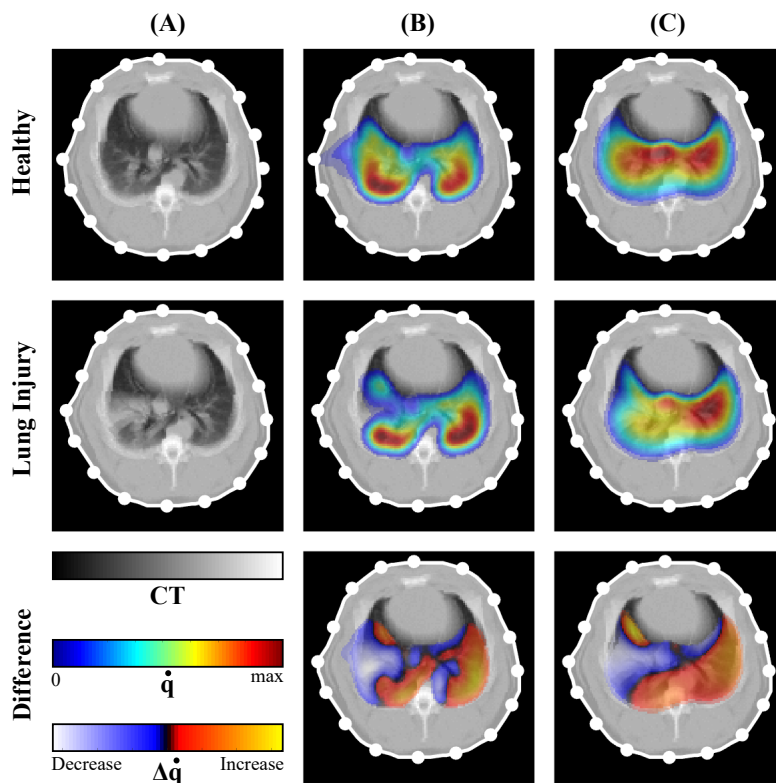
Estimated pulmonary perfusion distributions before and after sublobar lung injury. Static CT images (A) are shown alongside of the computed MDCT blood flow $\dot{q}_{CT,PCB}$ (B), the calculated EIT blood flow \dot{q}_{EIT} (C) for the healthy (upper row), and the injured lung (middle row). The spatial perfusion increase or decrease ($\Delta\dot{q}_{CT,PCB}$ and $\Delta\dot{q}_{EIT}$) after establishing regional lung injury is depicted in the last row. The images have been taken from our publication, which is currently under review.
